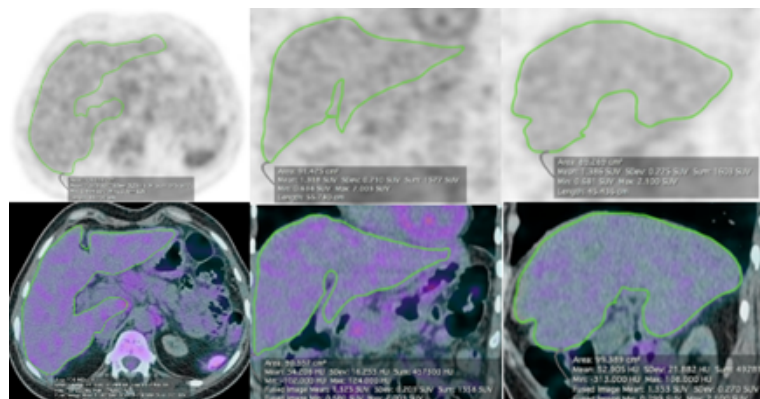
Axial, coronal, and sagittal views of regions of interest (ROIs) are drawn manually to calculate SUVmean (~1.3) and SUVmax (~2.1) in a whole cirrhotic liver. The first row is (18F-FDG PET) of the liver, and the second row is fused images of PET/CT.
